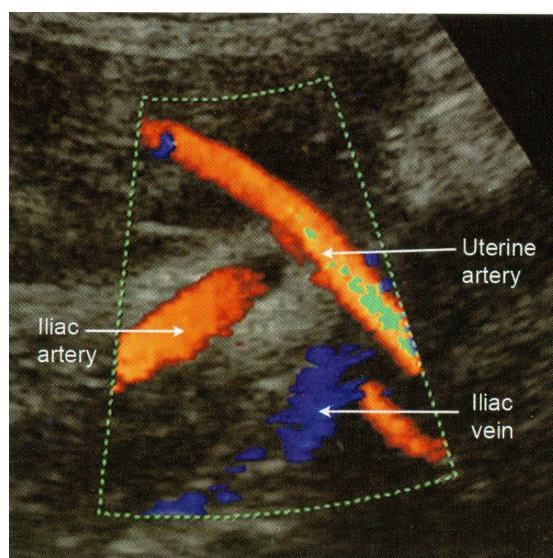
Uterine artery Doppler.
